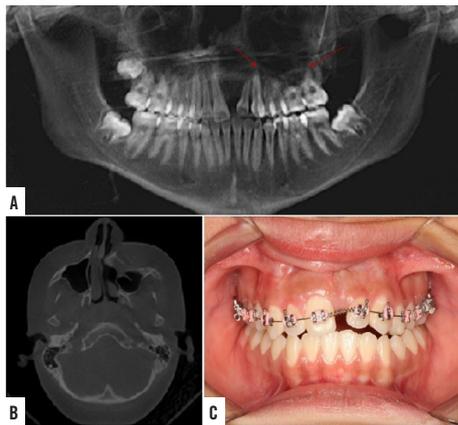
A) panoramic view; B) axial CBCT images taken one year after surgery showing evidence of bone formation in the region (red arrows); C) intraoral appearance one year after surgery
